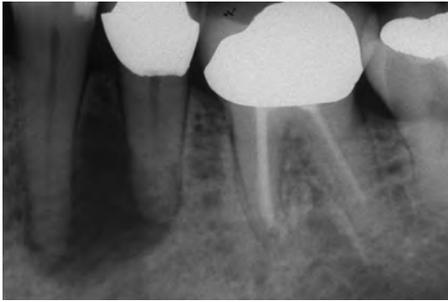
Periapical radiograph showing an ill-defined radiolucency at the apices of mandibular teeth. Image courtesy of Dr. Karim Alibhai.
